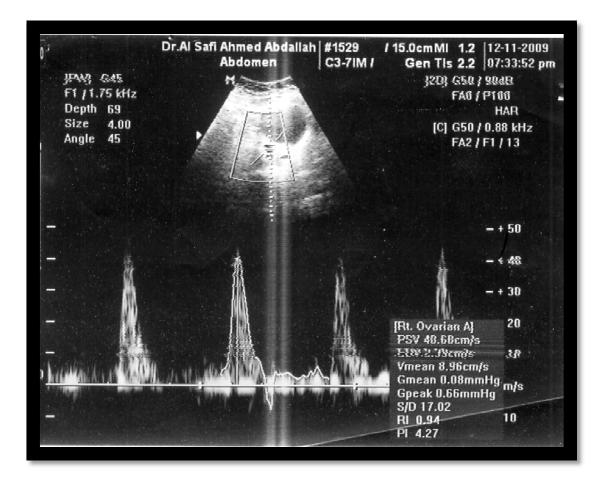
Sagittal abdominal color Doppler scan for uterine artery shows complete abortion this patient Has a history of recurrent abortion.
